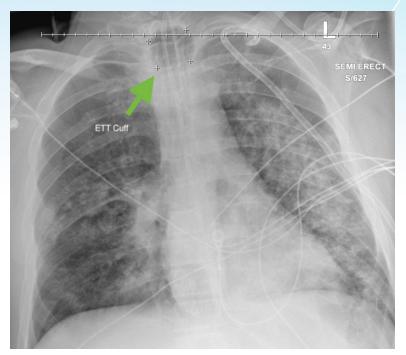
Chest X-ray from the morning of bedside tracheostomy. Note the enlarged endotracheal tube cuff, likely due to overinflation.
